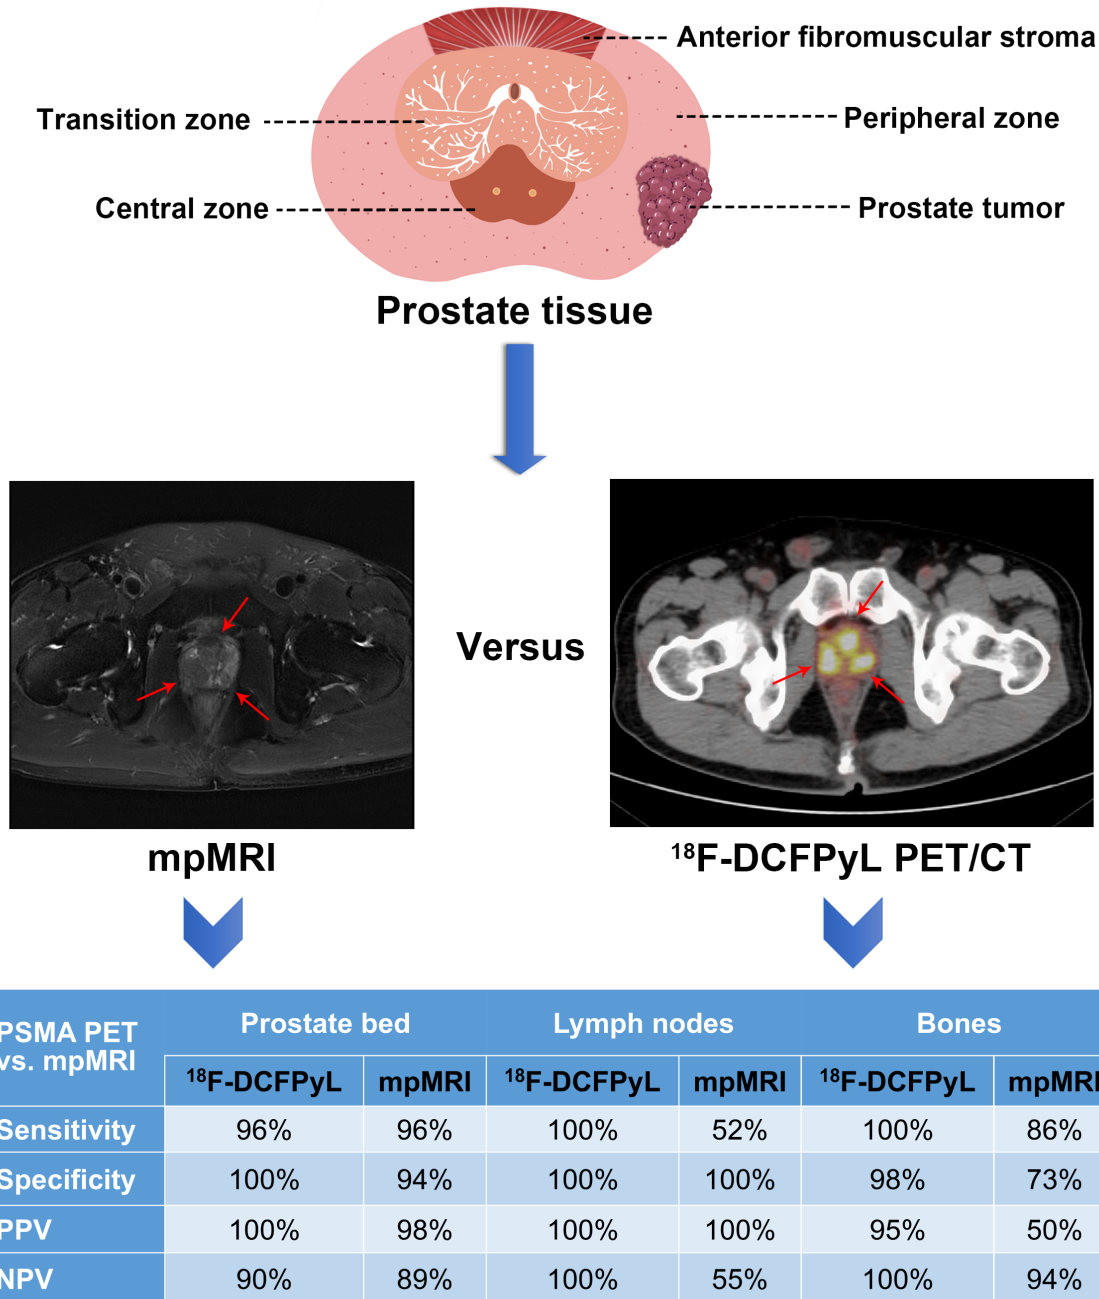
MpMRI and ¹⁸F-DCFPyL PET/CT imaging of prostate cancer. The table is concluded from Ref. [19]. PSMA-based ¹⁸F-DCFPyL PET/CT showed a higher sensitivity and negative predictive value (NPV) rate in lymph nodes, as well as higher sensitivity, specificity, positive predictive value (PPV) and NPV in bones.
